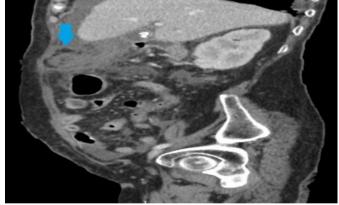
A sagittal section of an abdominal CT scan after injection of contrast, showing significant densification of the abdominal fat, creating a mass appearance with individualization of the whirl sign.
